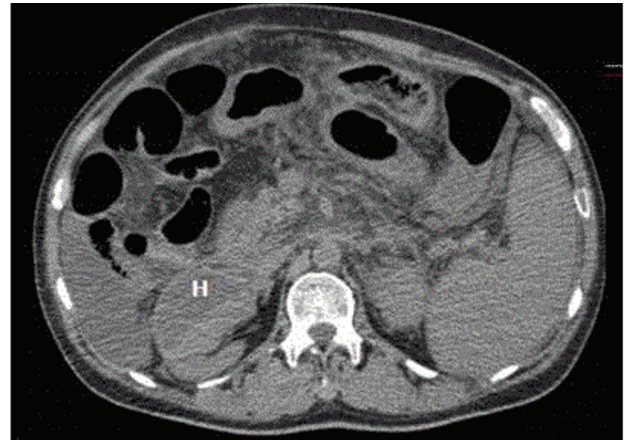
Abdominal CT scan without contrast enhancement. Resolution of subcapsular hematoma (H) in the right kidney was found 1 month later
